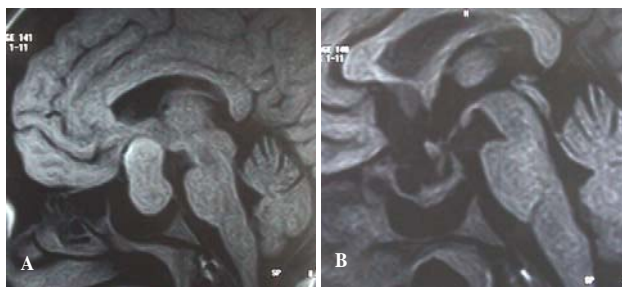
MRI of head, sagittal section, showing huge pituitary tumor with suprasellar (Hardy's B). A. Pre operative MRI. B. Post operative MRI showing complete resection.
